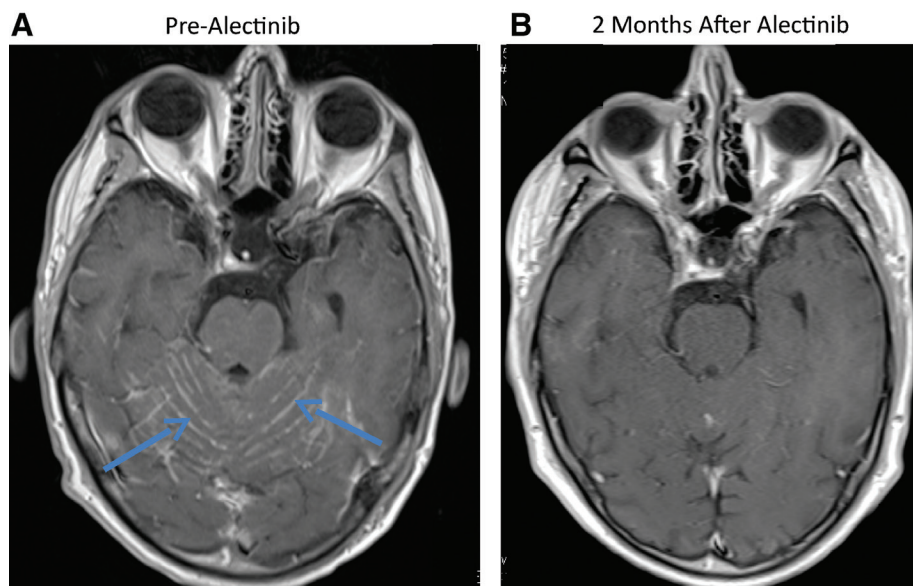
T1, post-gadolinium magnetic resonance images (MRI) depicting near complete resolution of leptomeningeal enhancement in a patient treated with alectinib. *A*, Before treatment with alectinib (blue arrows abnormal leptomeningeal enhancement). *B*, Two months after initiation of treatment with alectinib.
